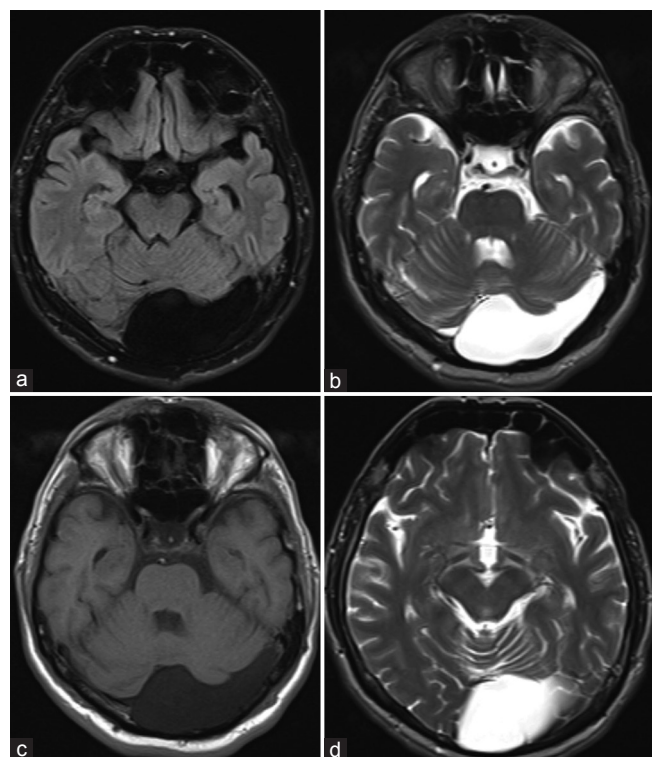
Cranial MRI FLAIR (a), T2 (b,d), and T1 (c) axial sequences of Case 2. MRI: Magnetic resonance imaging, FLAIR: Fluid-attenuated inversion recovery
